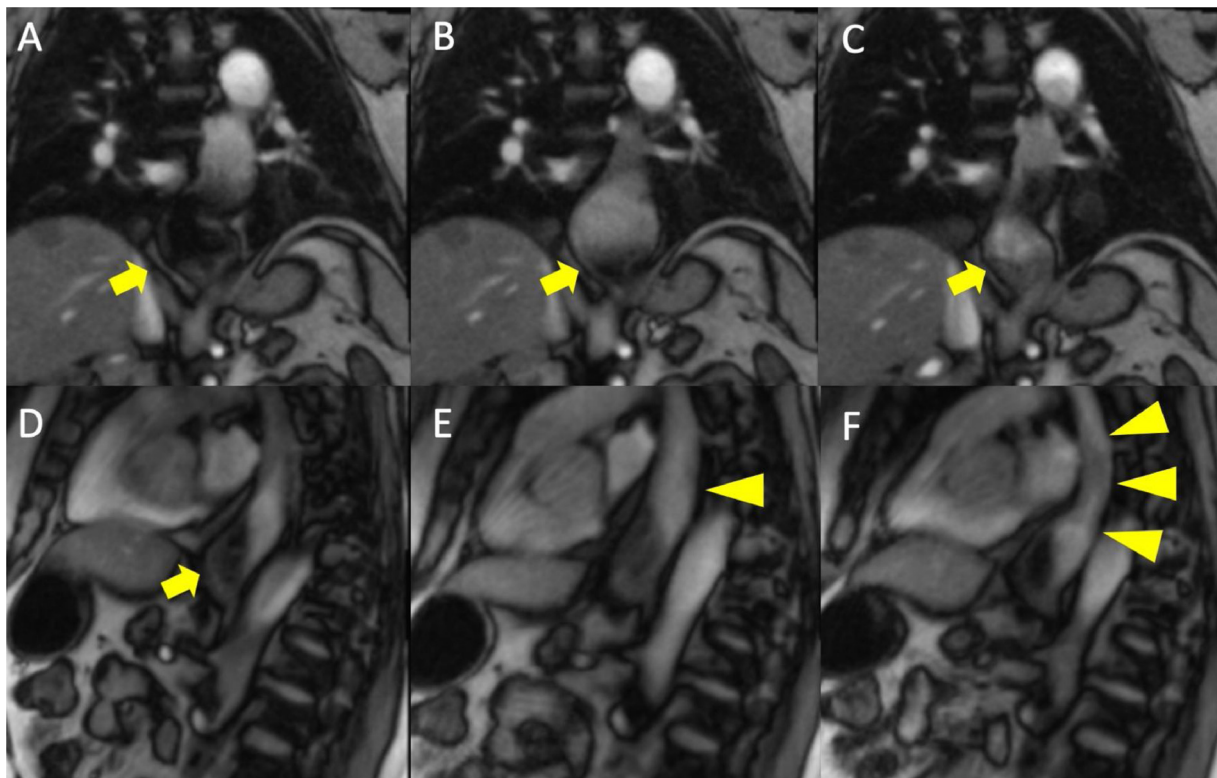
Real-time MRI of the bolus passage in coronal planes (A–C) and after Valsalva maneuver in sagittal planes (D–F). All real-time MRI images show a large hiatal hernia. The patient had no pathologic reflux on pH-metry, however, reflux was detected on real-time MRI and on impedance. Representative individual images were selected showing bolus passage in coronal planes (A–C). Sagittal planes reveal the extent of the herniation (D, arrow) and spontaneous reflux (E, arrow head). An increased reflux can be observed after performing Valsalva maneuver (F, arrow head). Also see supplemental Video 3.
